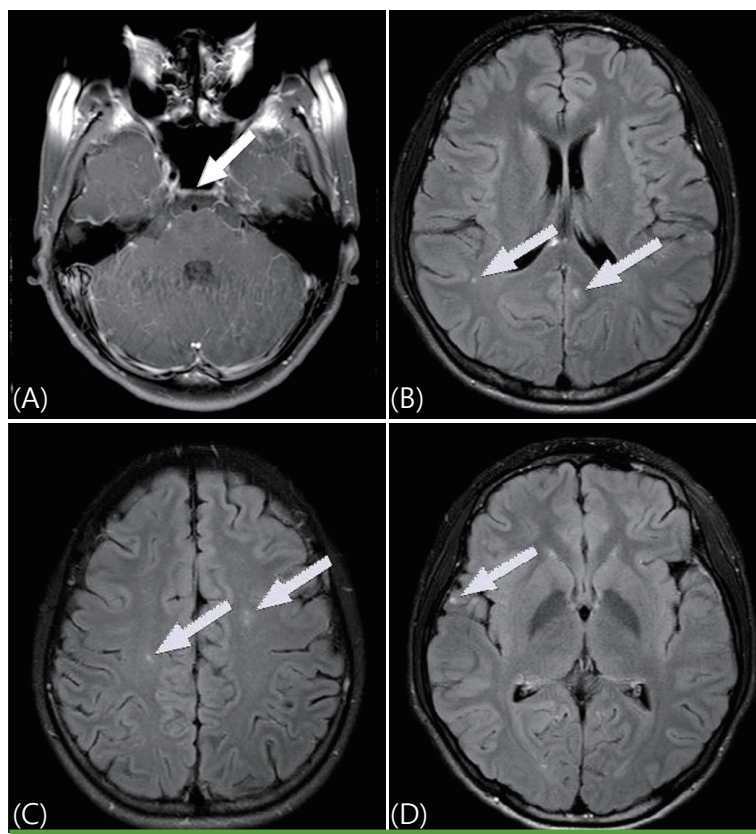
T1-weighted magnetic resonance image of the brain showing diffuse pial enhancement in the brainstem (A). T2-weighted magnetic resonance images of the brain showing enhancement in the left precuneus and right opercular gyrus (B), and multifocal lesions predominantly within the centrum semiovale (C) and right parietotemporal white matter (D).
